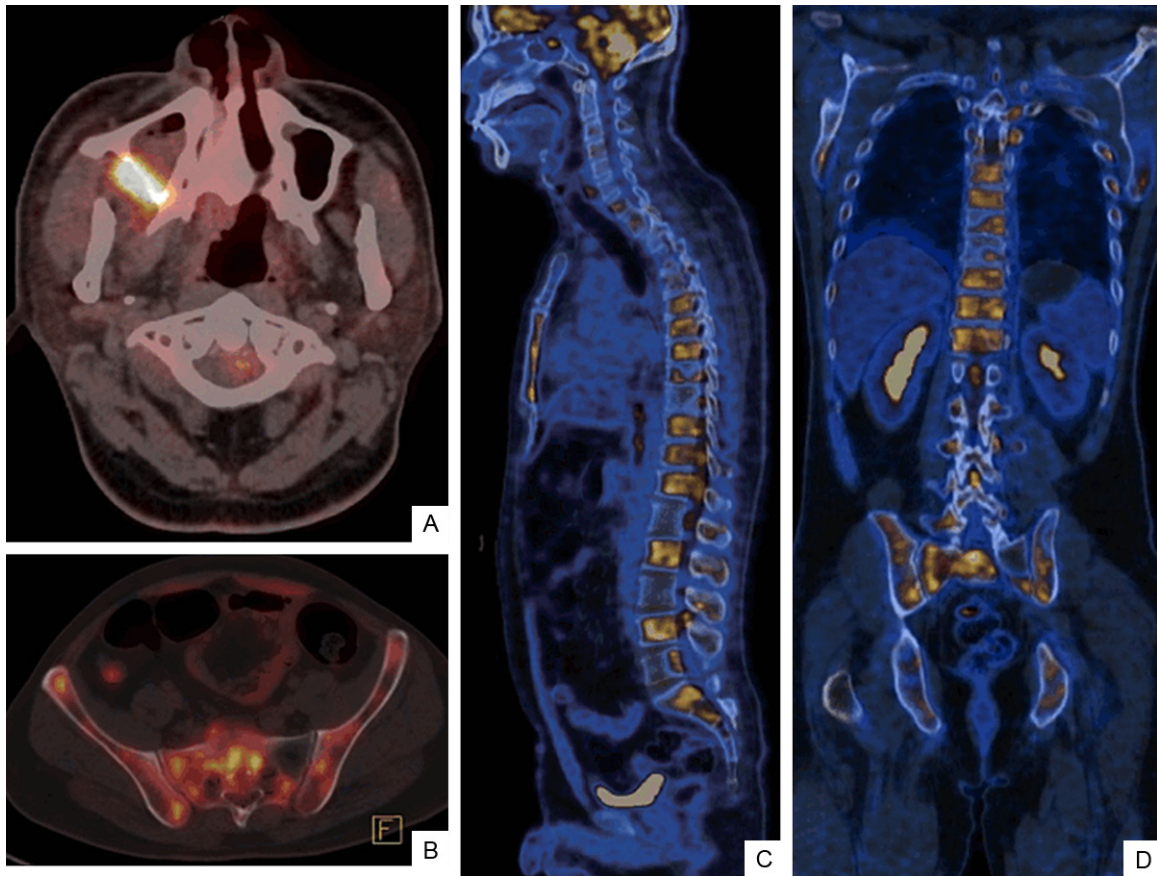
PET-CT images of multiple bone metastases. A: Lesions of the right maxillary sinus posterior wall. B: Lesions of the sacrum and bilateral iliac. C and D: System bone metastasis; Most of the whole body bone metabolism increased significantly.
